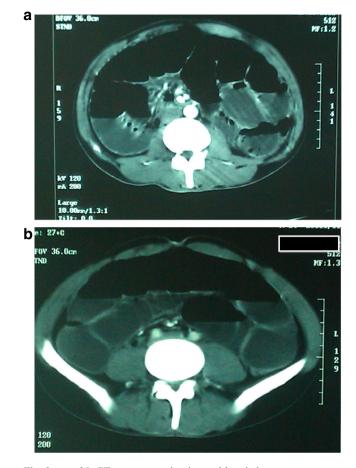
a and b CT scan suggesting internal herniation
